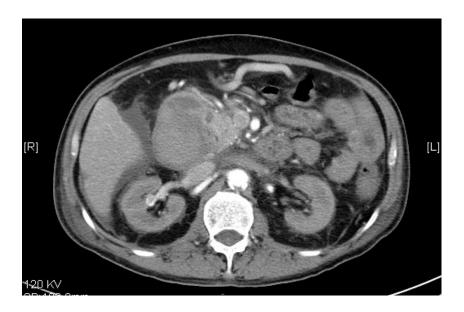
Computed tomography revealed a big intramural hematoma in second and third portion duodenum with infiltrative hematoma in bilateral anterior pararenal space.
